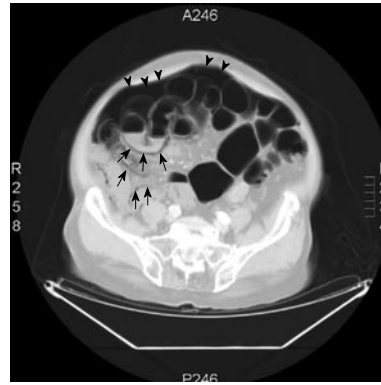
Use of lung window setting in abdominal computed tomography scan revealed massive intraperitoneal free air (arrowheads) and diffuse air collected within the bowel wall (arrows).
